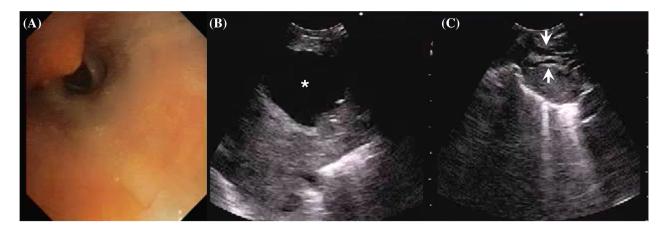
(A) Endobronchial nodule in the right main bronchus; (B, C) endobronchial ultrasound images showing aneurysmal right upper lobe pulmonary artery (asterisk) and vascular channels in the surrounding soft tissue (arrows).
